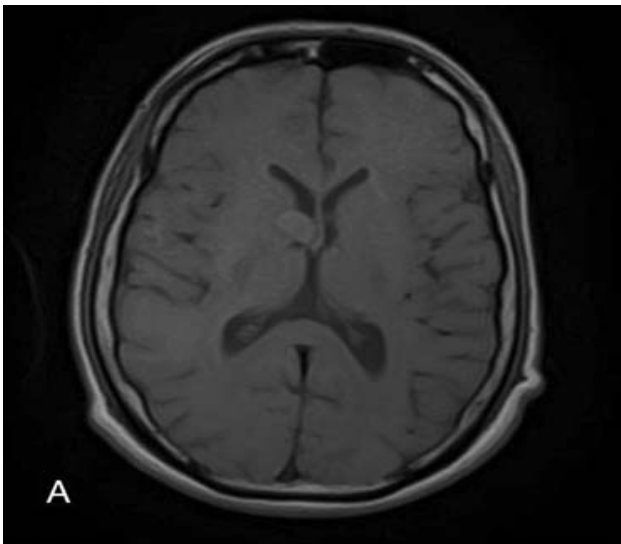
SEGA MRI (A: T1, B: T2, C: Flair, D: T1 Post-contrast)
